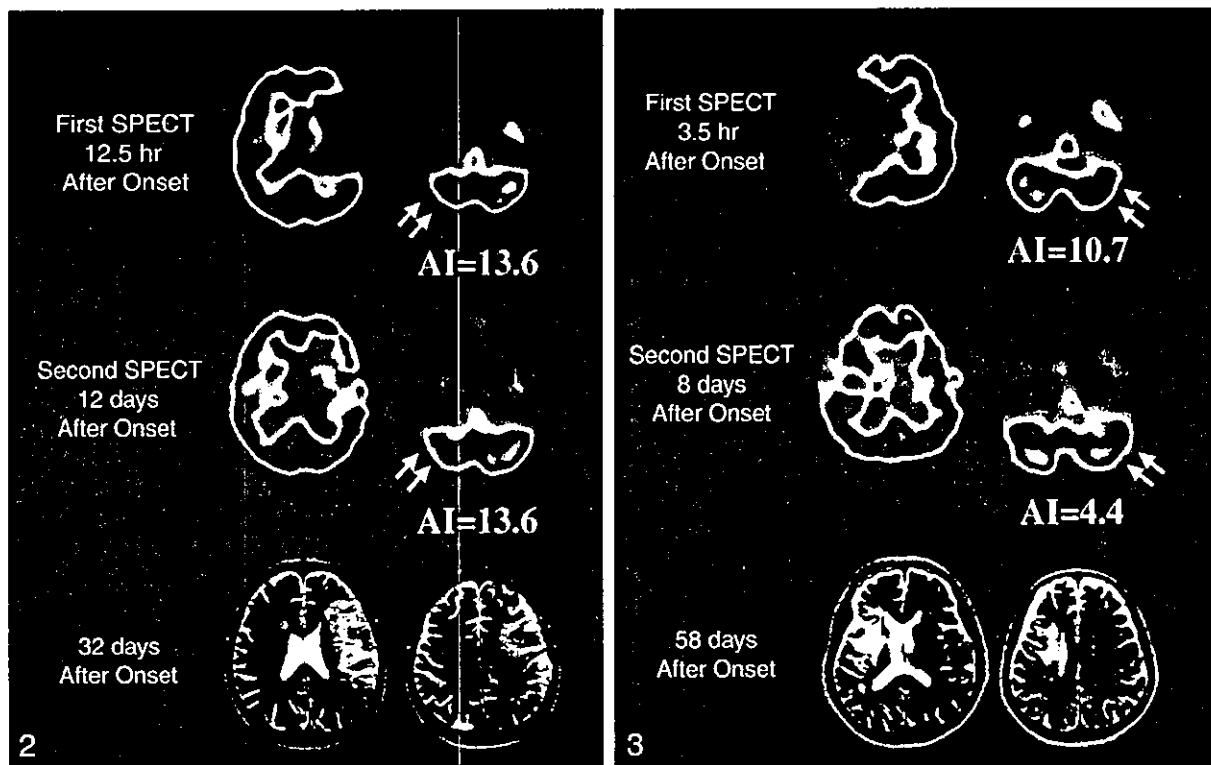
SPECT images obtained in patient 1 show severe cerebellar hypoperfusion (arrows) in both the acute (top row) and subacute (middle row) stages. This patient had SSS scores of 13 at admission and 38 at 60 days after onset. MR images (bottom row) obtained at 32 days show a large infarct in the left hemisphere.
